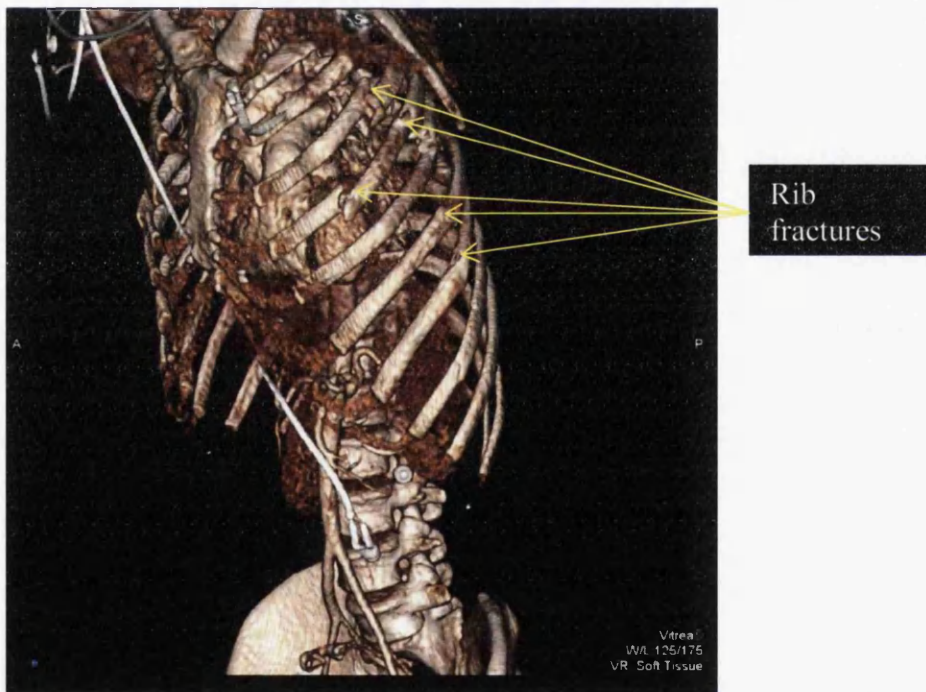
3D CT reconstruction of blunt chest wall trauma (lateral).
